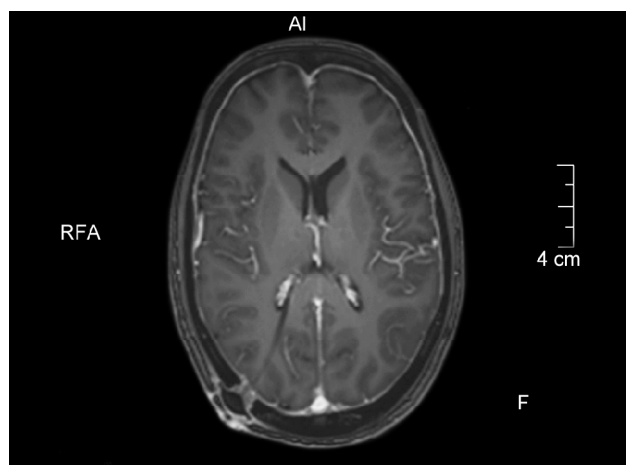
Contrast-enhanced MRI brain T1W axial image showing diffuse pachymeningeal enhancement
